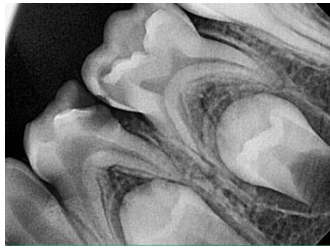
X-ray of teeth 84, 85
